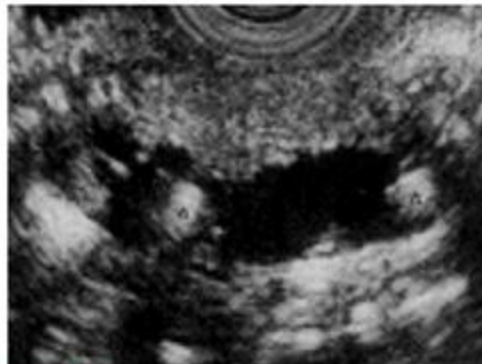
Endoscopic ultrasound in 54-year-old patient with chronic pancreatitis as a result of alcohol abuse. Note the marked
